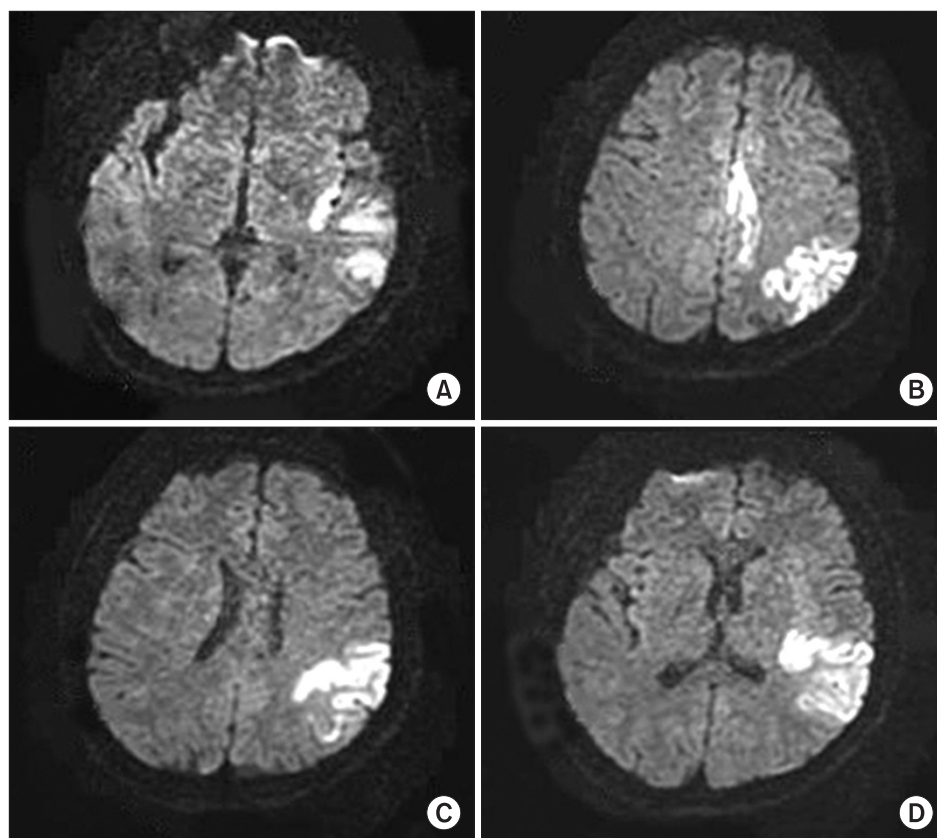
MRI images show infarcts in the left hemisphere. (A) insular and temporal (B) medial, frontal, and parietal; (C) parietal; (D) temporal.
